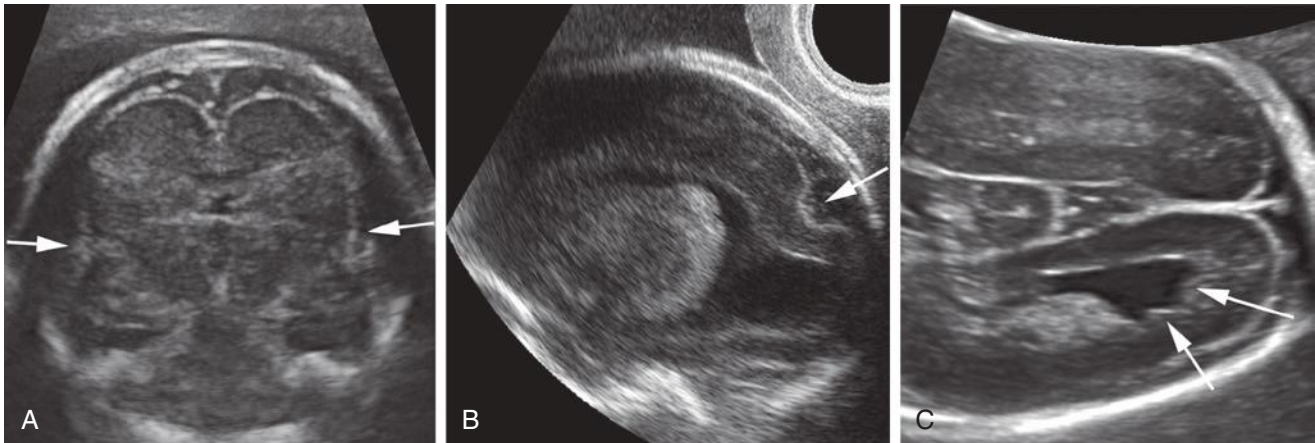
Cortical malformations (see [Table 9-12](#)). A, Lissencephaly; in this third trimester fetus, the brain contour appears abnormally smooth on this coronal ultrasound image, without evidence of convolutions or development of the sylvian fissures (*arrows*). B, An irregular sulcus/infolding (*arrow*) is noted in this fetus, diagnosed after birth with polymicrogyria. C, Irregular contour of the posterior aspect of the dependent lateral ventricle (*arrows*) suggests periventricular nodular heterotopia.
